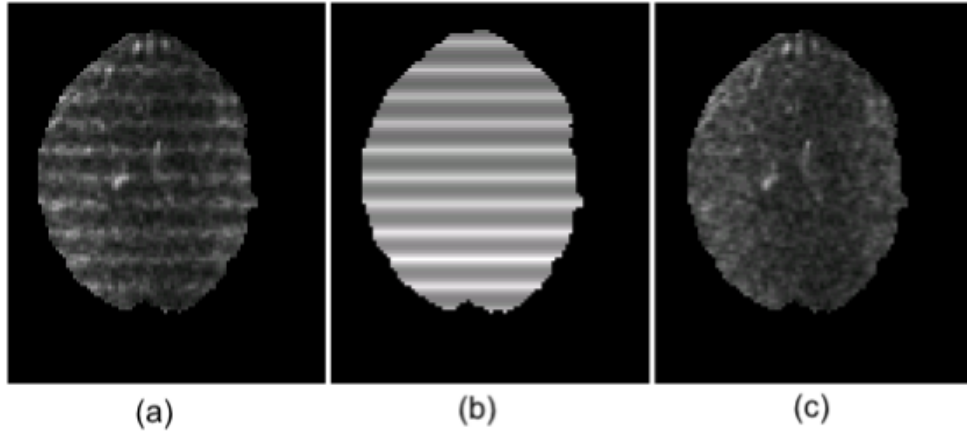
Demonstration of bias in χ^2 between the DT model and registered DWI data. Part (a) show the χ^2 map computed using a single value for the variance in the data. Part (b) shows the non-uniform variance estimated using formula (7.8). Part (c) shows the same χ^2 map, however, this time computed using the variance values displayed in part (b).
